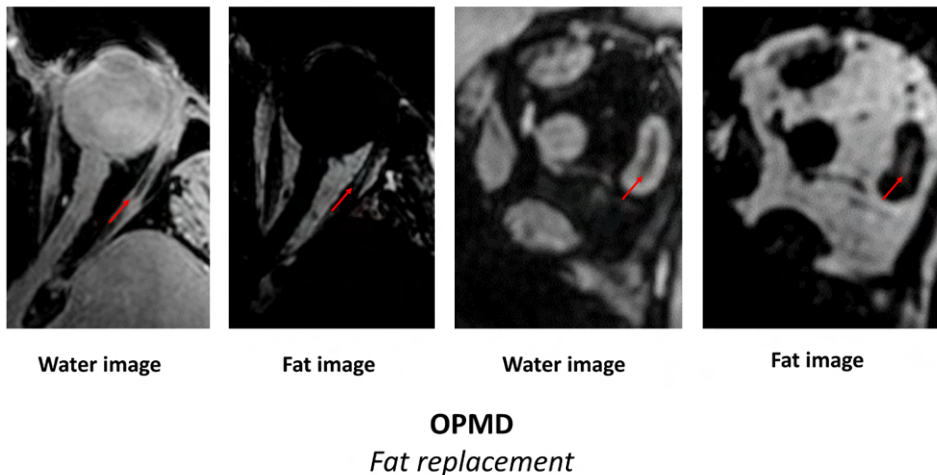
MRI scans of the orbit. Chemical shift based water-fat separation (using the Dixon technique) was used and the transverse water image (first), transverse fat image (second), the coronal water image (third) and the coronal fat image (fourth) are shown. This MRI scan demonstrates fat replacement of the EOM in a patient with OPMD. The fat replacement is predominantly observed in the lateral rectus muscles (red arrows).
